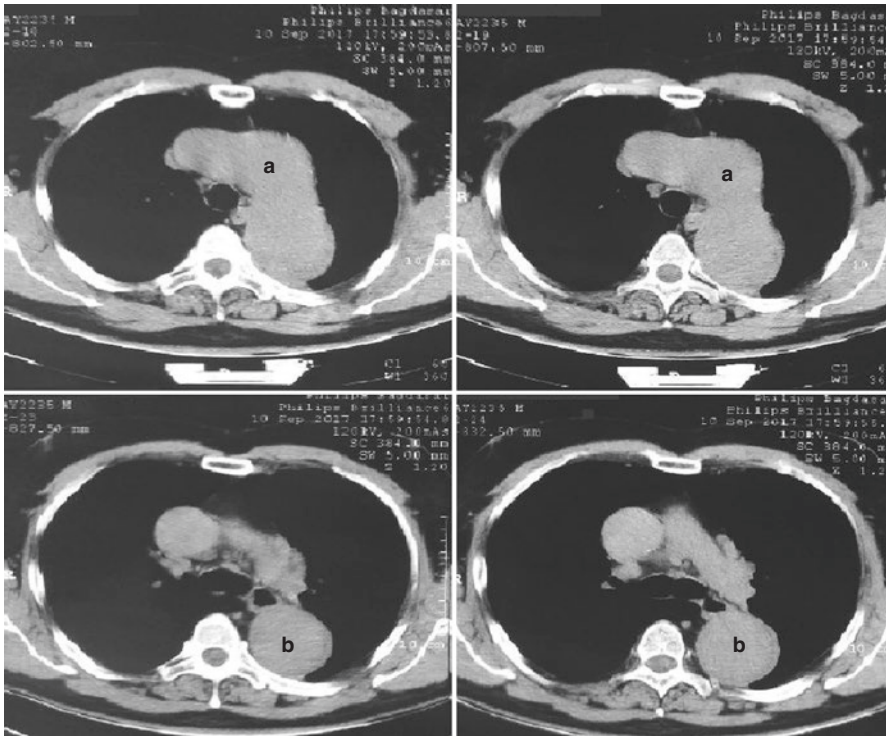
Axial thoracic CT scans—aneurysmal dilation at the level of the aortic arch (a) and descending aorta (b)
